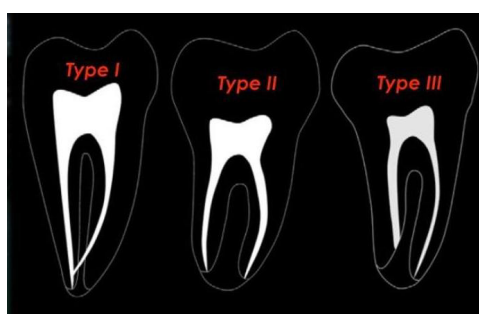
Fan C-shape classification by radiographic appearance
